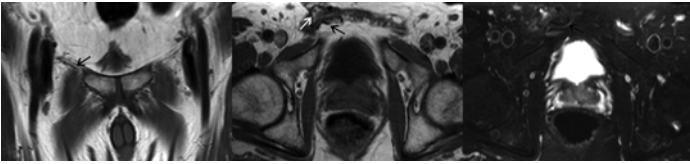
Coronal MR T1-weighted, axial T1-weighted, and axial fat-saturated T2-weighted images of flat mesh material (*black arrows*) closing an indirect defect of the right inguinal canal (*white arrow*). Flat mesh materials typically appear as a *thick hypointense line*. While there is some undulation of this mesh, there is no inappropriate folding and no significant mass effect to suggest meshoma or mesh reaction.
